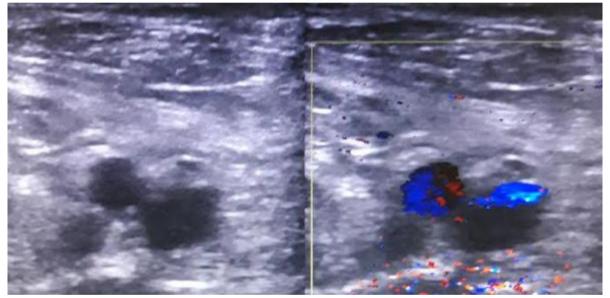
Sagital images of superficial femoral vein on grey and color Doppler showing thrombosis.
